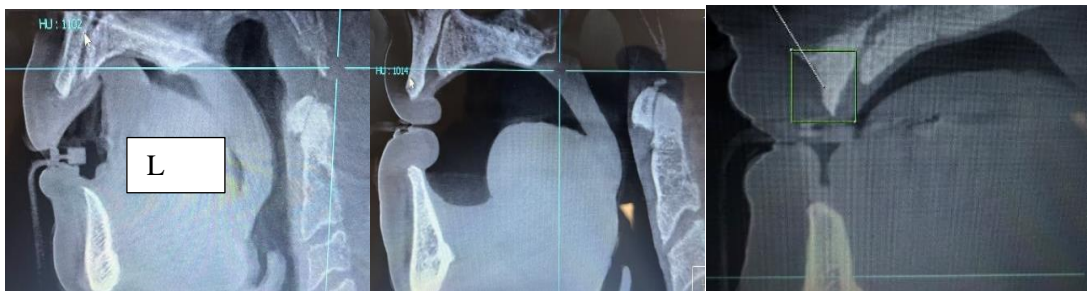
Descriptive analysis of Premaxilla crest outline in sagittal view of CBCT
